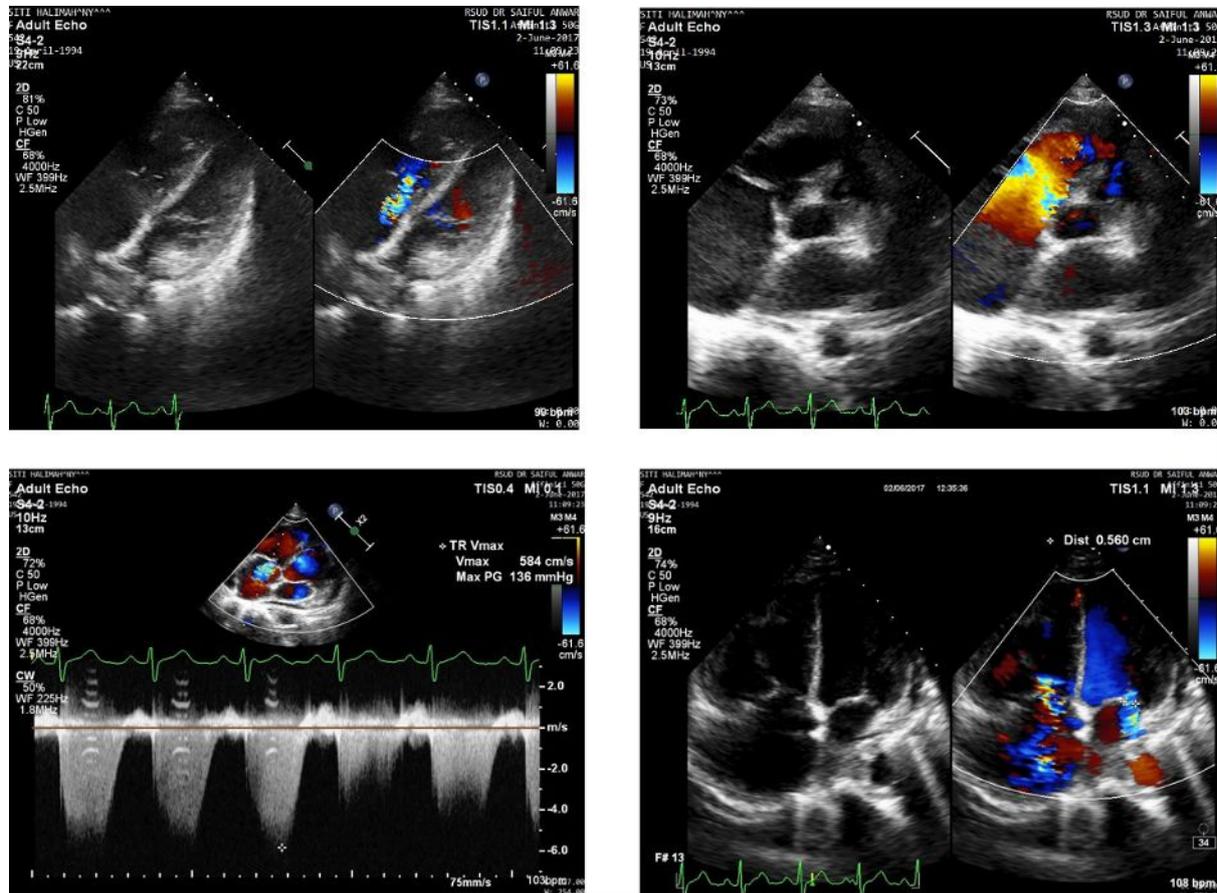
Echocardiography showed intact IAS, moderate pulmonary regurgitation, severe tricuspid regurgitation, dilated RV, mitral and aortic insufficiency.
